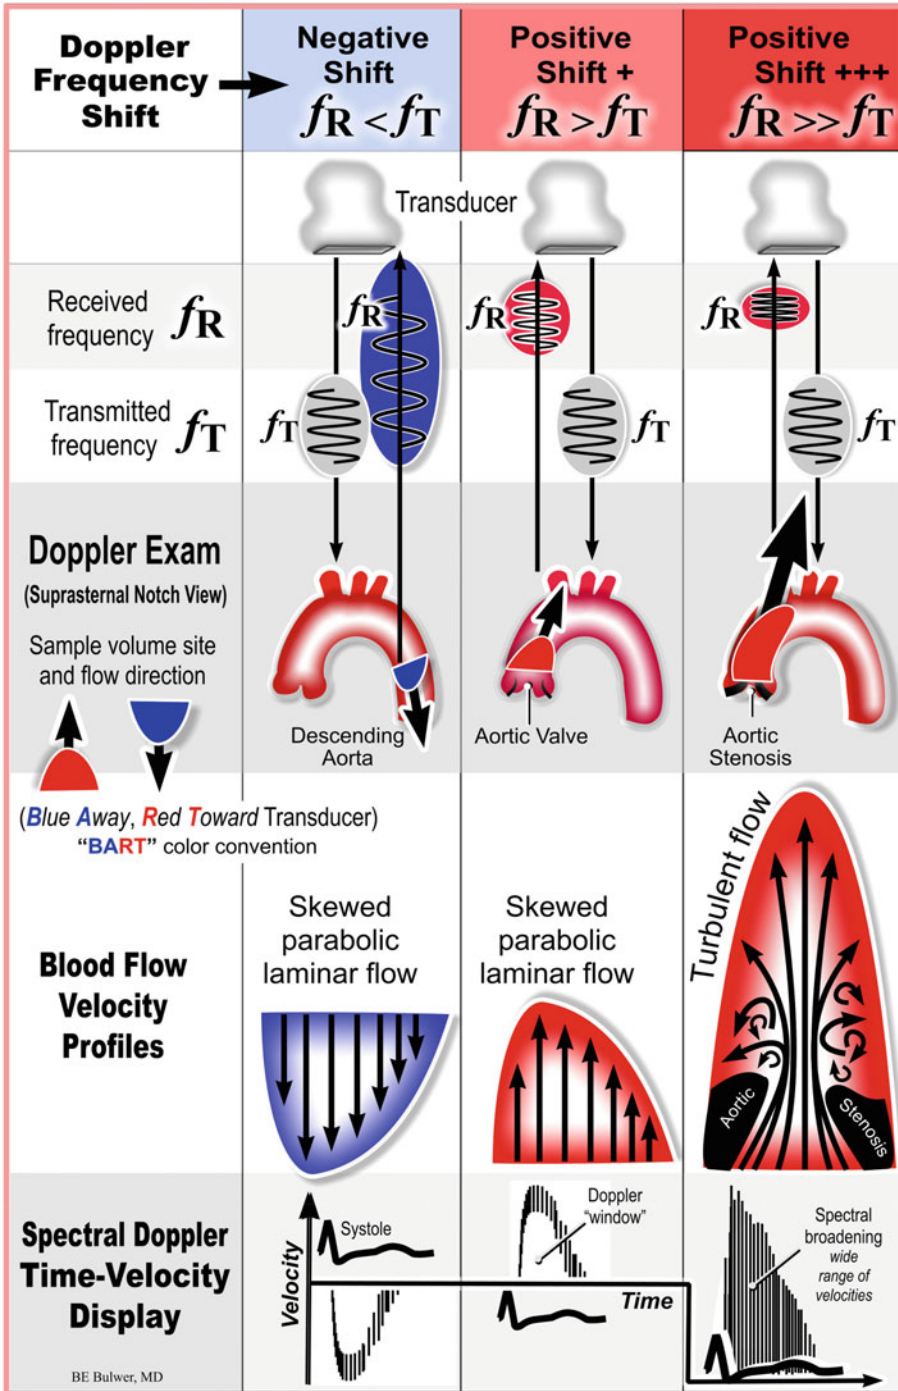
Summary of Doppler examination of flow within the ascending and descending thoracic aorta, using the suprasternal notch (SSN) window. Left column: Note (blue) flow within the descending thoracic aorta away from the transducer, with lower frequency echoes ($f_R < f_T$)—resulting in a negative Doppler shift. Center:
